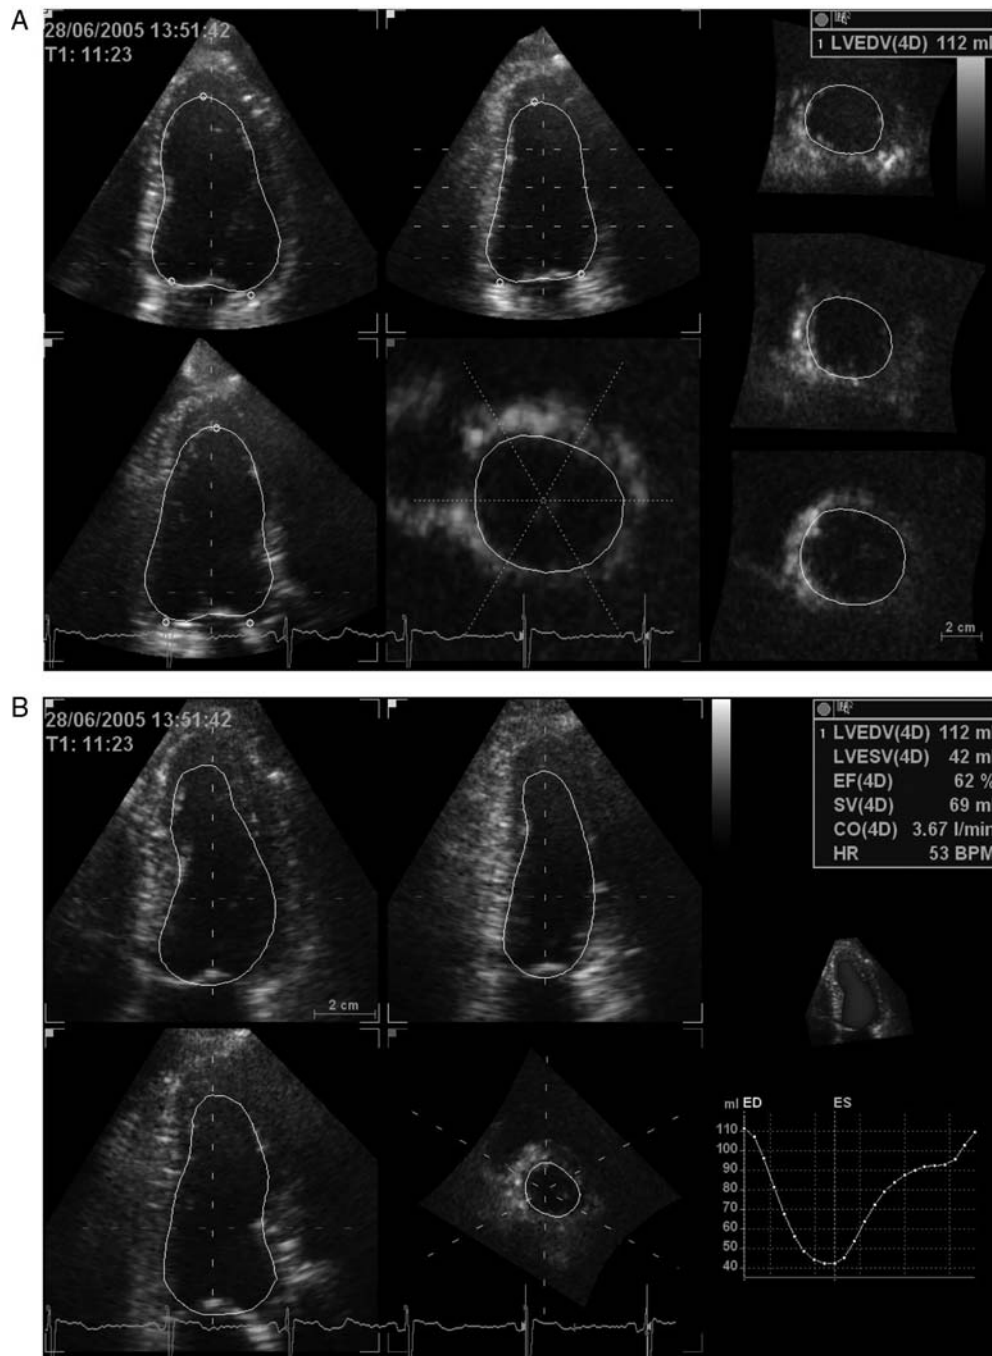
Left ventricular surface detection using 4D LVQ in EchoPAC software. (A) Borders are initialized by manual annotation of mitral valve annulus and apex in the standard apical views. Three extra SAX views were used to further verify the detected surface. (B) The complete four-dimensional surface detection at end-systole with time-volume curve. Courtesy of J. Hansegård (GE Vingmed Ultrasound, Horten, Norway).
